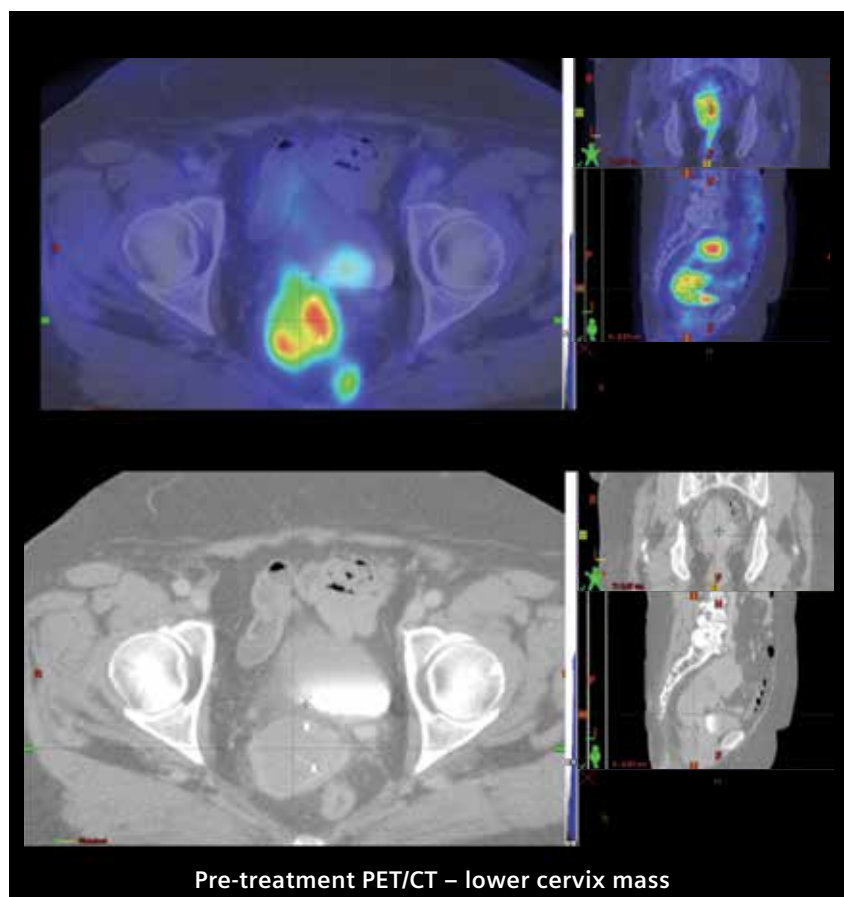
PET/CT at the level of the lower cervical mass also shows high tumoral tracer uptake.
